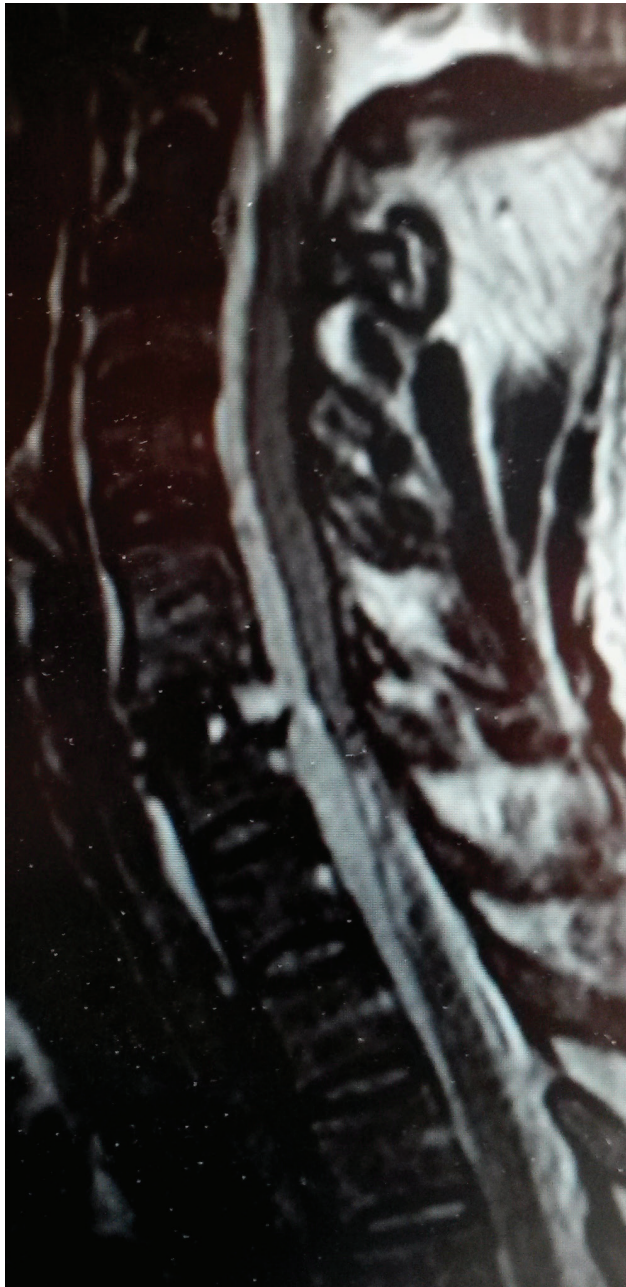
Postoperative sagittal T2-weighted cervical magnetic resonance imaging image shows epidural hemorrhage
